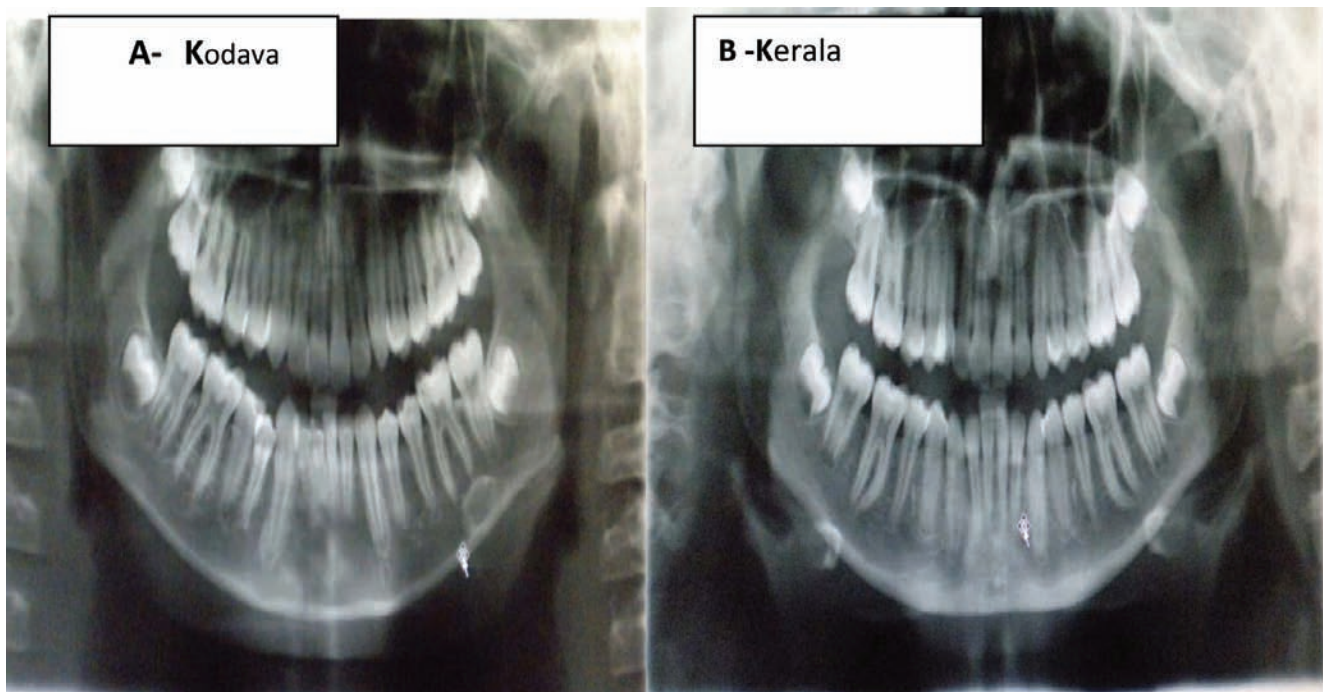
X-ray Showing OPG of A- Kodava And B Kerala
